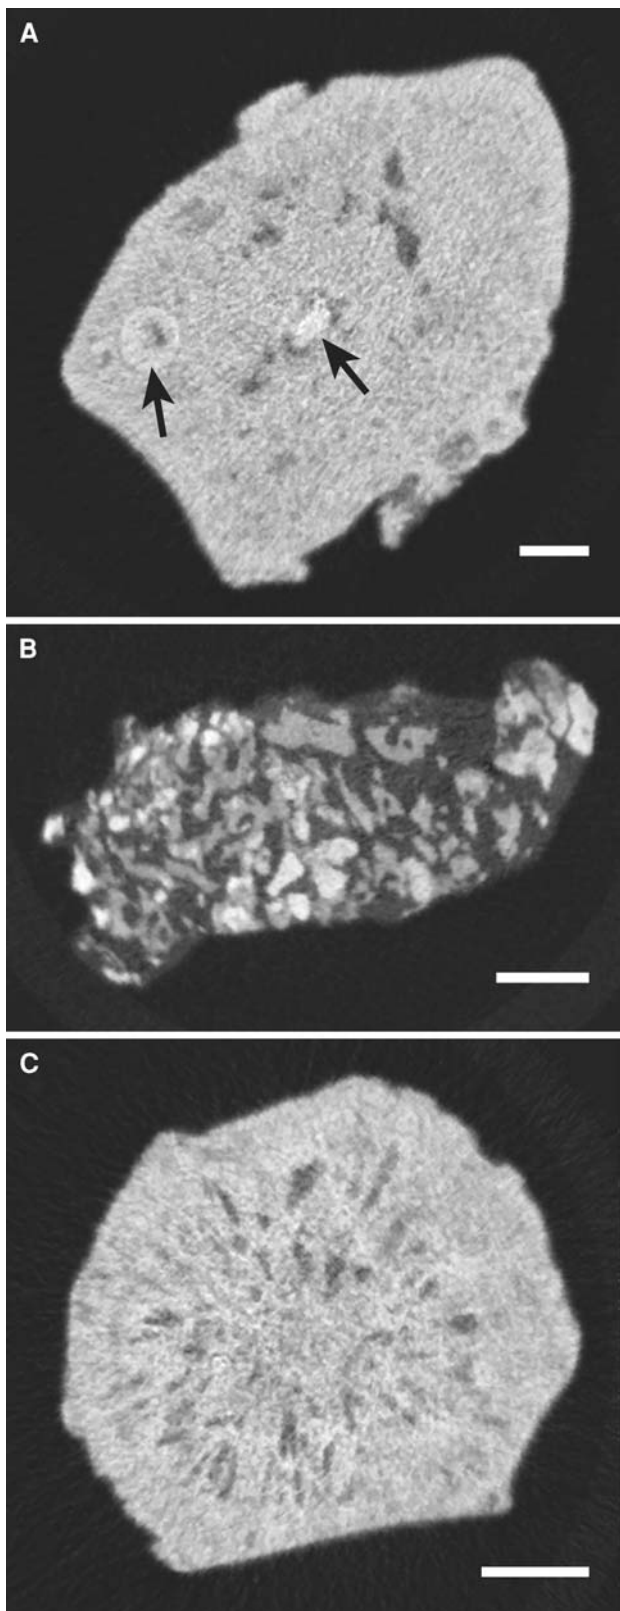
Micro CT slices of 3 ‘odd’ morphologies for apatite stones, found among the 15 stones in this study. a Stone was relatively solid, with isolated nodule-like structures within it (arrows). b Stone was composed of small pieces of apatite, each <0.5 mm, held together with an X-ray lucent material. c Stone contained many small voids, which were arranged radially about the stone axis. By FT-IR, this stone showed the presence of some amorphous calcium phosphate. Bars indicate 1 mm
